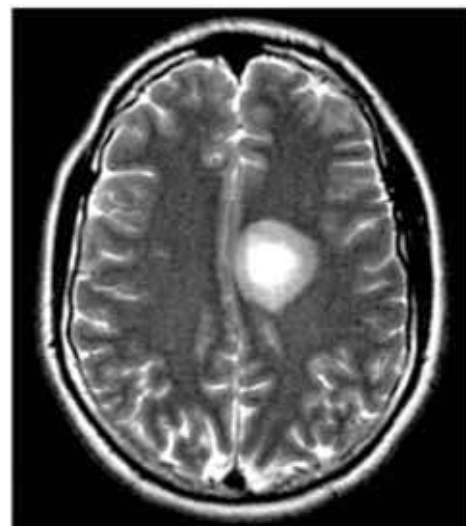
Case of MRI ADEM
